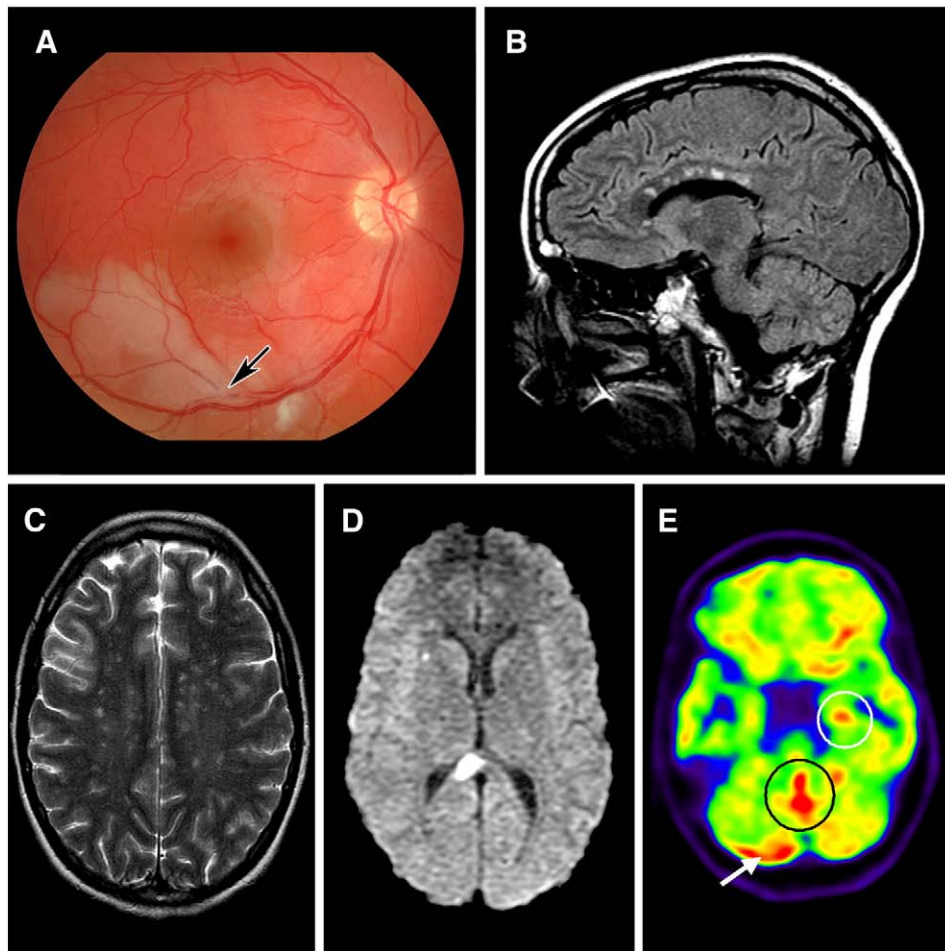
Susac's syndrome. Right fundus photograph (A) shows branch retinal artery occlusion (arrow) and associated retinal infarction. Brain MRI sequences showing typical 'snowball' corpus callosal lesions (B), numerous foci of increased T2 increased signal in the deep white matter of both hemispheres (C) and a large right splenial lesion (D) exhibiting restricted diffusion in keeping with acute infarction. FDG-PET imaging (E) shows hypermetabolism in right lateral cerebellar hemisphere (white arrow), the cerebellar vermis (black circle) and the left parahippocampal gyrus (white circle).
